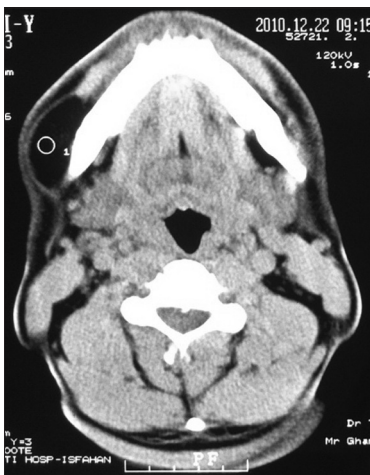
Axial omnipaue contrast CT scan of the lesion
